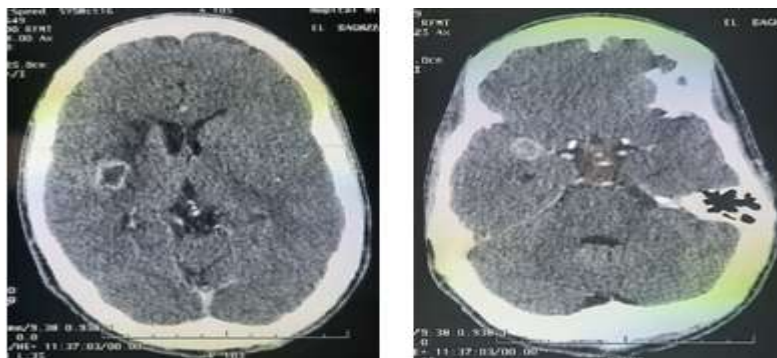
A and B: MRI showing multiple ring-enhancing lesions of various sizes in the right parietal lobe
